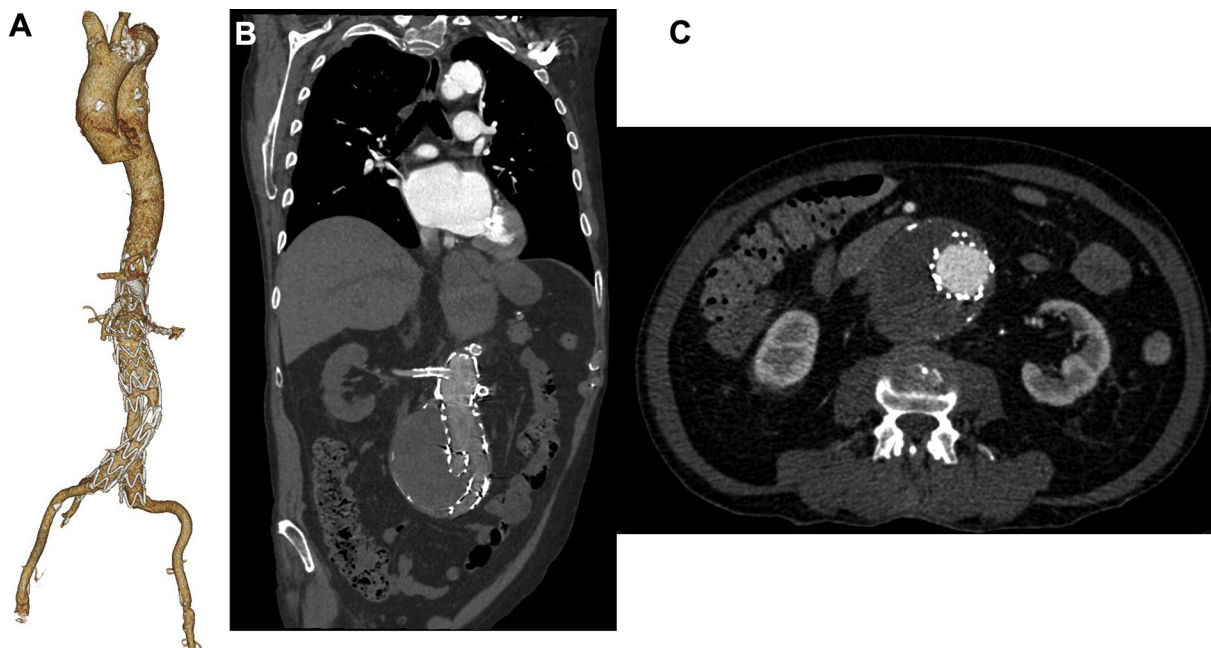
Computed tomography (CT) scan at 1-year follow-up after proximal extension and in situ laser fenestration with total exclusion of the aneurysm with three-dimensional volume rendered reconstruction (A) and coronal (B) and axial (C) views.
